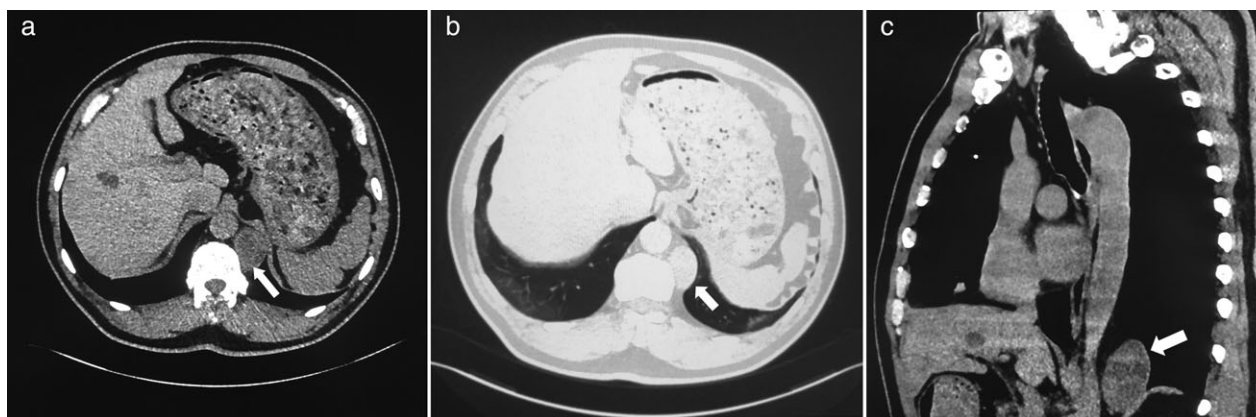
(a) Computed tomography image showing a left lower posterior mediastinal paravertebral tumor measuring 4.2 × 3.0 cm in diameter (arrow). No direct invasion of the tumor to any adjacent structures was observed. (b) The tumor (arrow) was located in the mediastinum. (c) No blood vessel connection was observed between the tumor (arrow) and the descending aorta.
